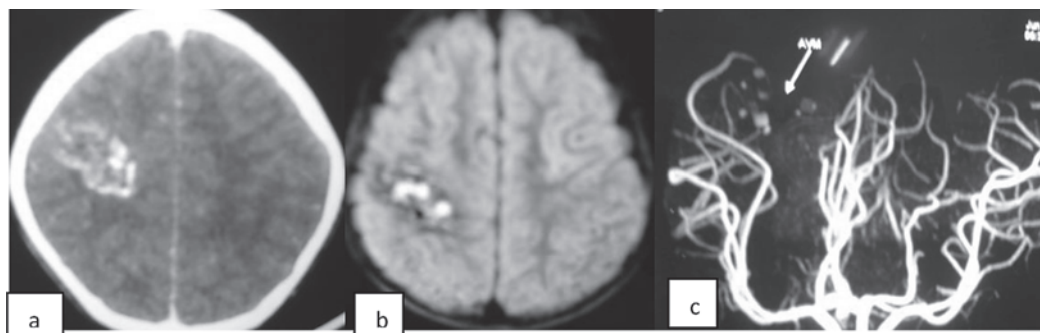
Contrast CT showing enhancement of feeding vessels. b. Axial FLAIR image shows conglomeration of flow voids forming a “honeycomb” pattern. c. MR Angiography showing AVM
